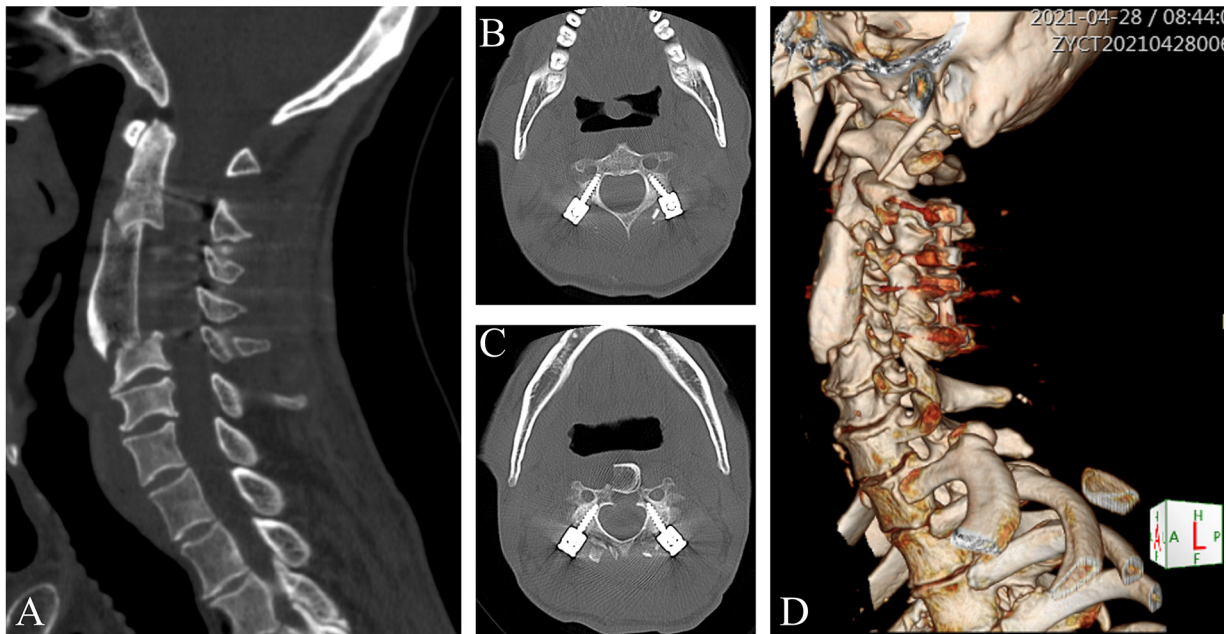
CT image of the spine 1-month post-surgery. A, Cervical CT sagittal view of the C3/C4 intervertebral body with the bone graft in place. B-C, Axial view with internal fixation in the pedicle. D, 3D CT reconstruction.
